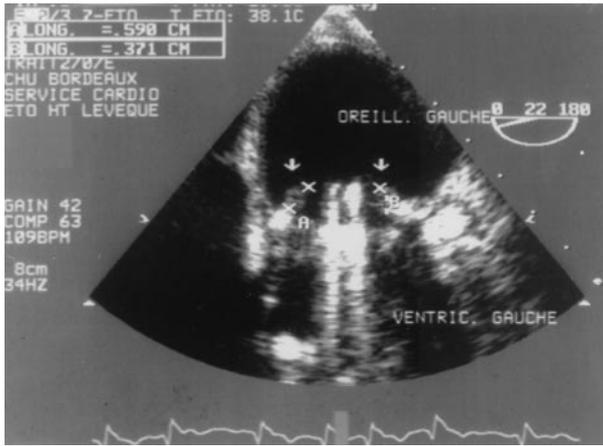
TEE view of a St. Jude medical mitral valve showing nonobstructive thrombus on the atrial side of the prosthesis. TEE = transesophageal echocardiography.
